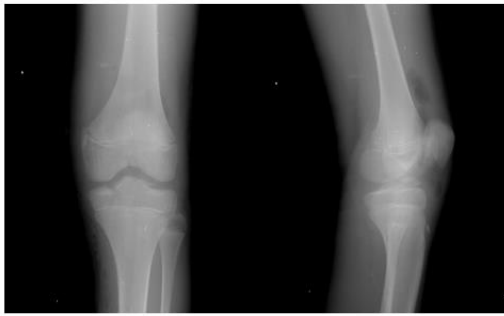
Left Knee X-ray AP/lateral view post operation shows fracture fragments already reduced and compressed.
